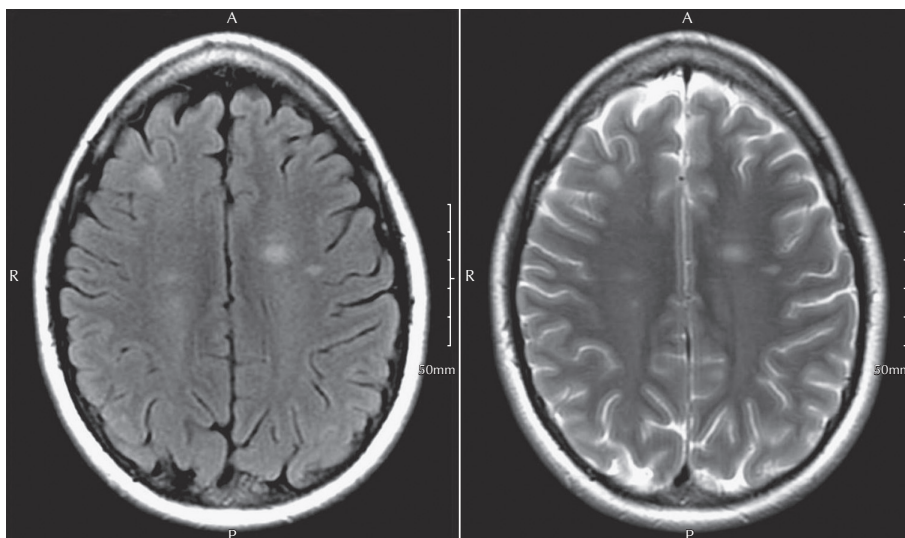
FLAIR and T2W axial images demonstrate hyperintensities in the right frontal and left frontal white matter.
